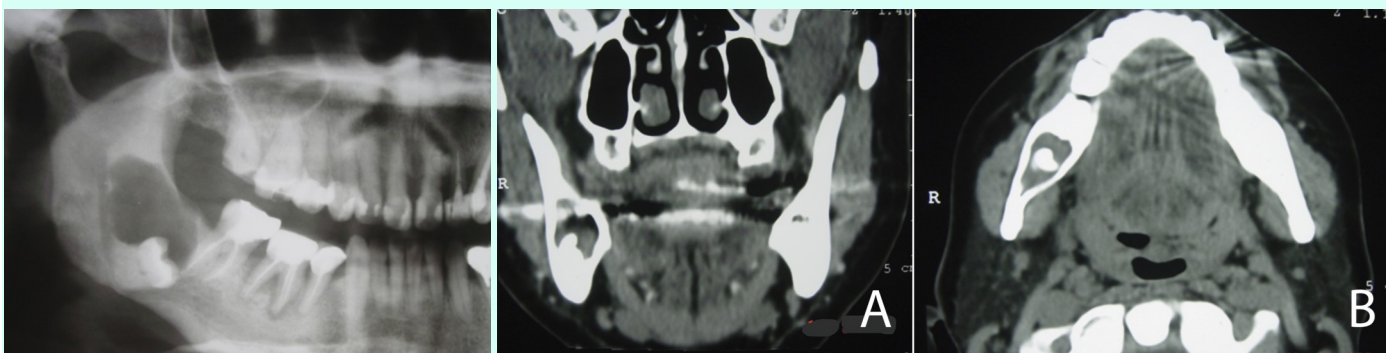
Routine radiographic examination (panoramic radiography) presenting radiolucent lesion involving unerupted tooth 48.
